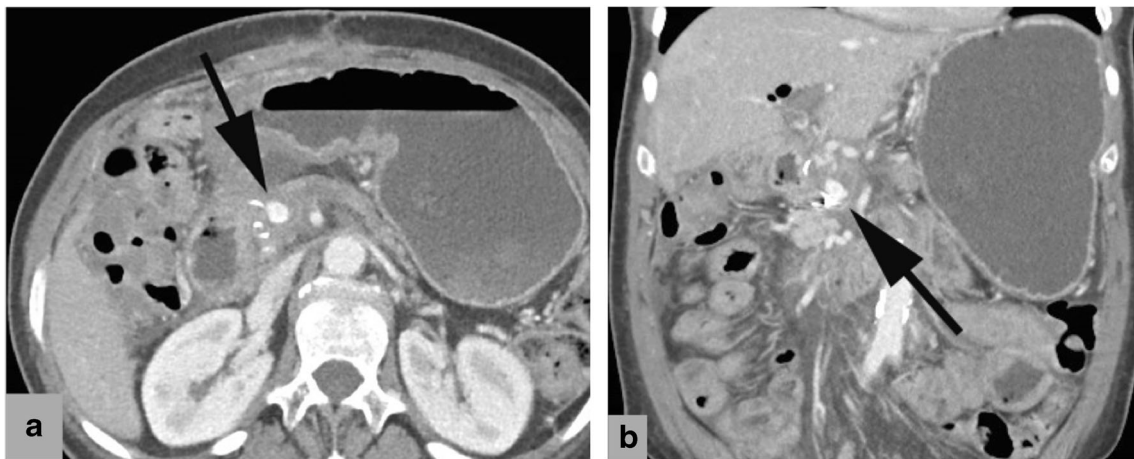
Sixty-nine-year-old woman with 3 days of melena following pancreaticoduodenectomy. Source of hemorrhage is a GDA pseudoaneurysm (arrows) bleeding into the duodenum. The GDA stump should be carefully evaluated in axial (a) and coronal (b) planes on IV contrast-enhanced CT. The absence of hemorrhage into the duodenal lumen does not diminish the critical nature of this finding.
